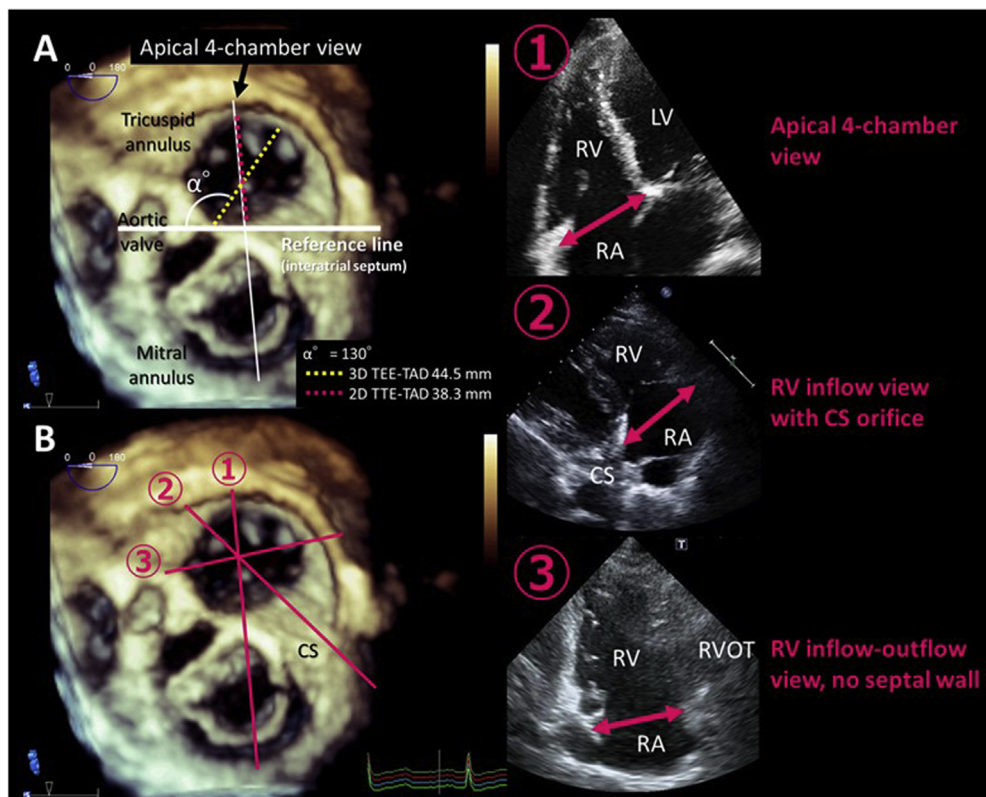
The angle difference between major TA axis and various 2D TTE planes. (A) A representative case with large absolute value of $90^\circ - \alpha^\circ$ and posteriorly displaced TA presenting a large bias of 6.2 mm between 3D TEE-TAD and 2D TTE-TAD. The solid white line represents the reference line parallel to the interatrial septum. (B) Orientations of various 2D TTE planes for the measurement of TAD including the apical four-chamber view, RV inflow view with CS orifice, and RV inflow-outflow view approximately parallel to the coronal section of the RV. It can be seen that none of these three 2D image planes captures the largest TAD. CS, Coronary sinus; LV, left ventricle; RA, right atrium; RVOT, RV outflow tract.
